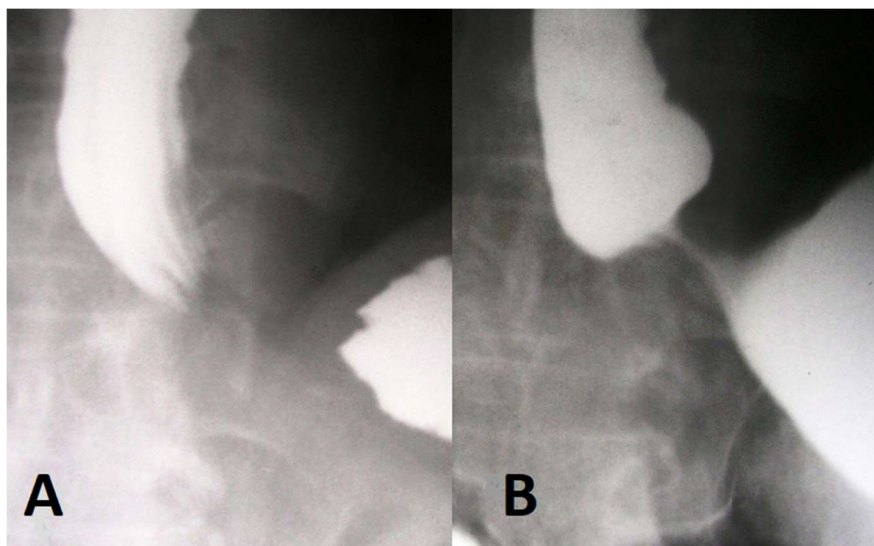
Radiographs of GEJ of adult patient during the abdominal compression. A) There was a contraction of the LES; B) In the process of compression, angular deformity of the stomach appeared as a result of the opening of the abdominal portion of the LES. The expansion of the esophagus over the LES appeared (Phrenic ampulla).
